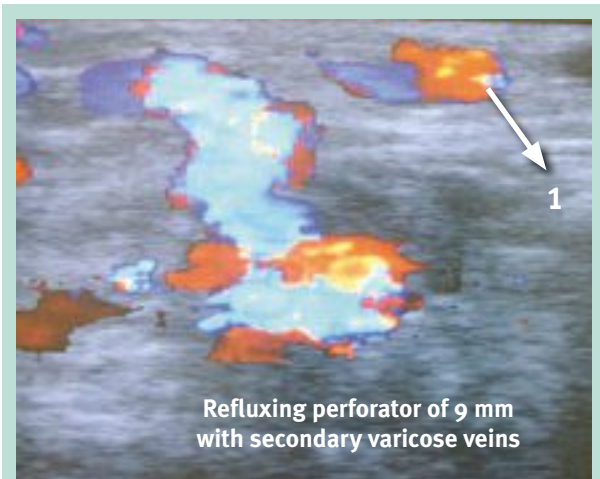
Echo-Doppler photo that shows the reflux in the secondary varicose vein.
